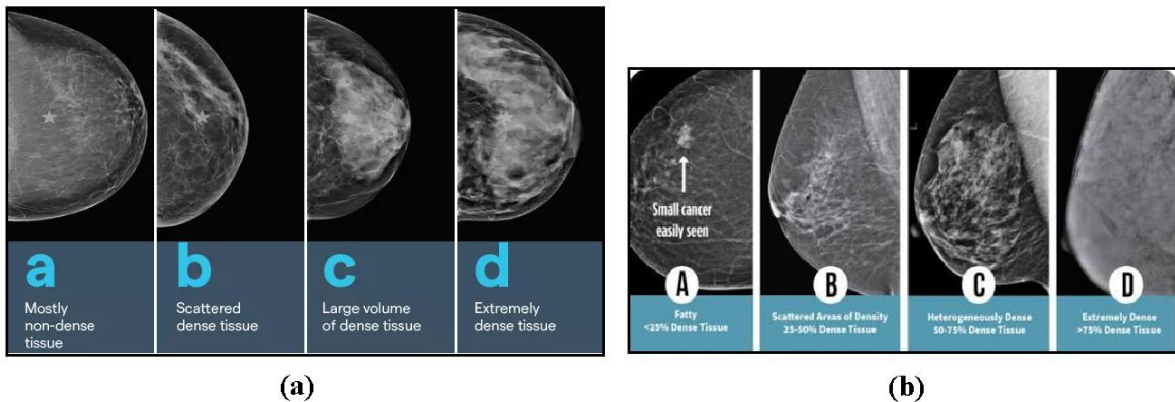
Photographs of (a) mammography, (b) breast ultrasound
